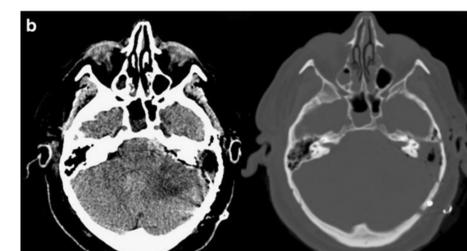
Figure b. Immediate post-operative CT scan
